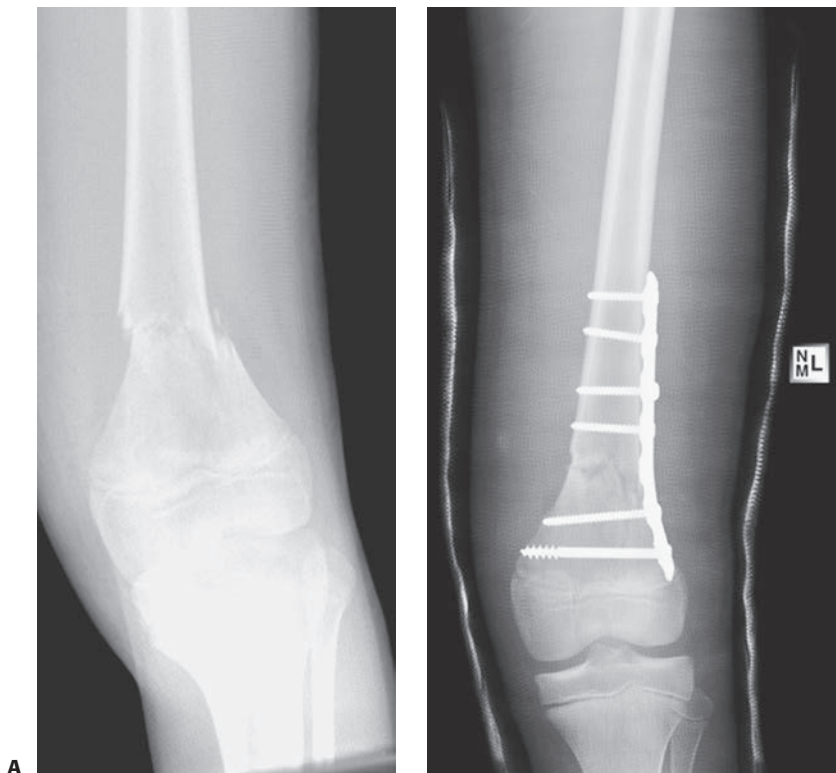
Preoperative (A) and postoperative (B) x-rays showing a fracture at the junction of the distal femoral metaphysis and diaphysis treated with plate fixation.
